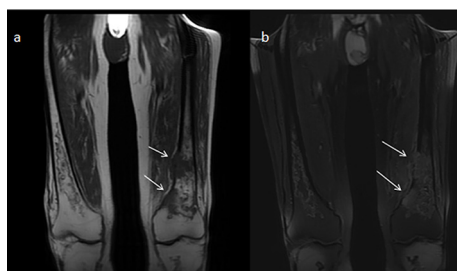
T1-weighted (A) and T2-weighted fat saturated (B) MRIs reveal medullary bone infarcts in distal diaphysis–metaphysis of the distal femur and proximal tibia bilaterally. In this left infarct area, there are multiple lesions (arrows) causing cortical destructions with soft tissue components and the largest one is measured 4×2.5 cm.
